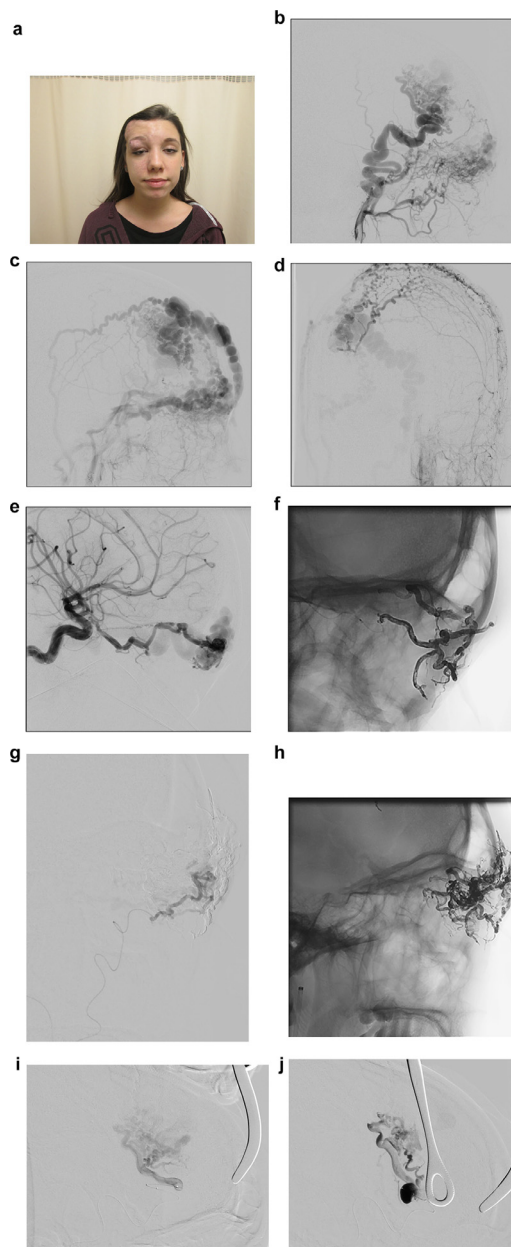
(a) Patient with a frontoorbital AVM complaining of palpebral ptosis, pain, and esthetic prejudice. (b,c) Right external carotid angiogram in lateral projections showing a type IIb Cho and type II Yakes AVM with multiple feeders coming from internal maxillary, middle meningeal and temporal arteries. (d) Injection in the left external carotid in AP projection showing contralateral recruitment. (e) Internal carotid angiogram showing a recruitment through a supraorbital branch of the ophthalmic artery. (f) Embolization with Onyx of the supraorbital branch. (g,h) Onyx embolization of feeders arising from an infraorbital branch coming from the internal maxillary artery. (i) Catheterization of the temporal branch feeding the main nidus in the scalp (j). Embolization with ethanol using external compression with forceps to block venous drainage (k). Good occlusion of AV fistulas on control DSA. (l) Catheterization of a frontotemporal branch (m), embolization with ethanol to induce endothelial ablation and slow the flow (n) Direct puncture of the venous drainage under ultrasound (o) and ethanol embolization with external compression (p). The first temporal branch was then occluded with onyx (arrow) and the frontotemporal branch with glue (arrowhead). (q,r) Control DSA before resection surgery showing minimal residual opacification of the nidus. (s) Patient evolution following surgery.
